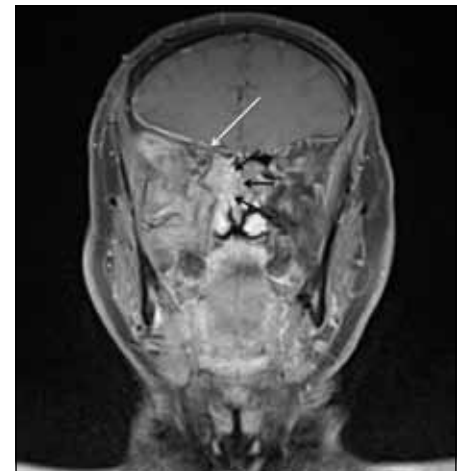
Coronal T1 gadolinium-enhanced magnetic resonance imaging showing the meningioma extending through a widened foramen ovale (white arrow) into the infratemporal fossa, and the right nasal cavity (black arrows) at the level of the middle meatus.
